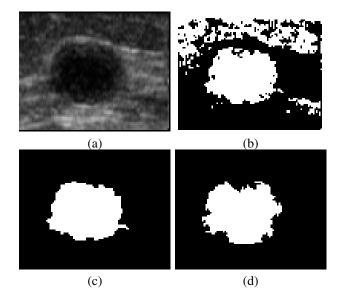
(a) original ultrasound benign image; (b) NESRA segmentation with two recursions and q = 0.0001; (c) ROI after morphological chain application; (d) ROI after level set application.
